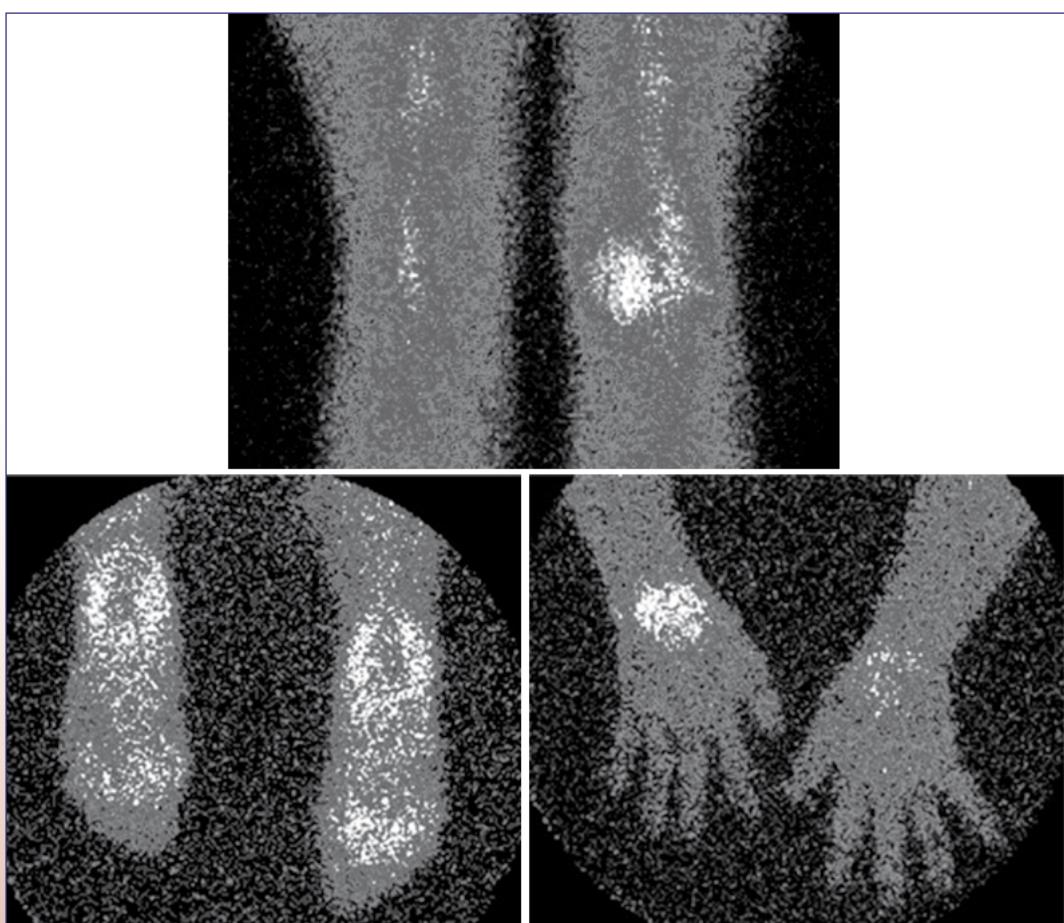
Multiple joint (knee, ankle, wrist) involvement in patients with Rheumatoid Arthritis, as demonstrated by scintigraphy with $^{99m}\text{Tc}-\text{TNF}\alpha$ monoclonal antibody.
